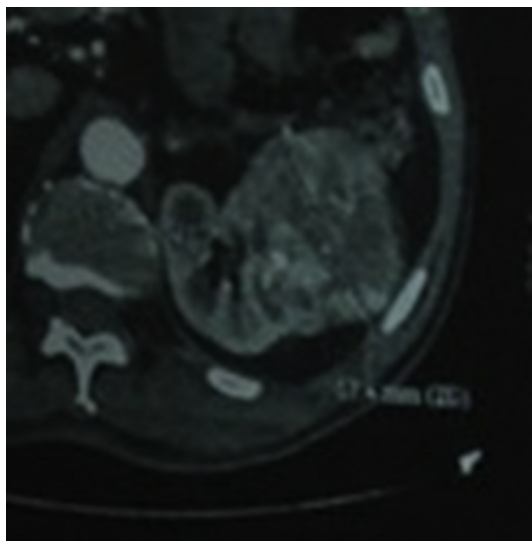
Abdominal CT revealed a left renal cell carcinoma.
